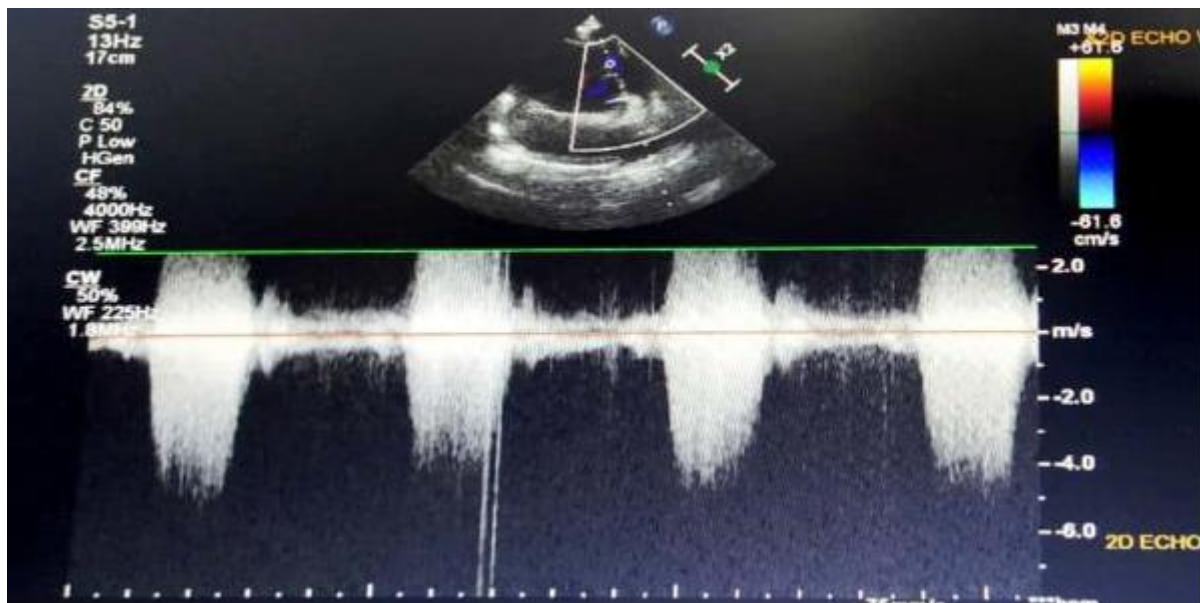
(a): Echocardiogram showing abnormalities pre surgery
